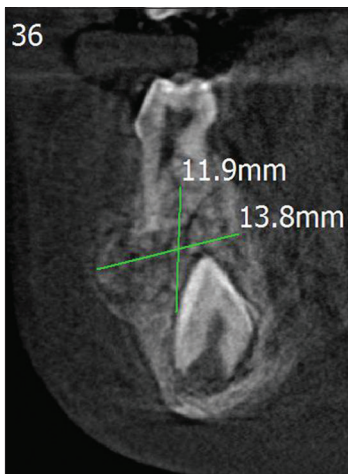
Cone beam computed tomography approximate maximum dimensions of the lesion (11.9 mm × 13.8 mm)
